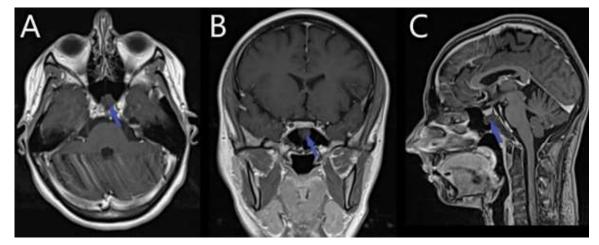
(A, B, C). MRI of the brain and paranasal sinuses with intravenous contrast (gadolinium) in a T1-weighted sequence of the axial, coronal, and sagittal slices show a hypointense, moderately enhancing tumor formation within the sphenoid sinus (blue arrow)
